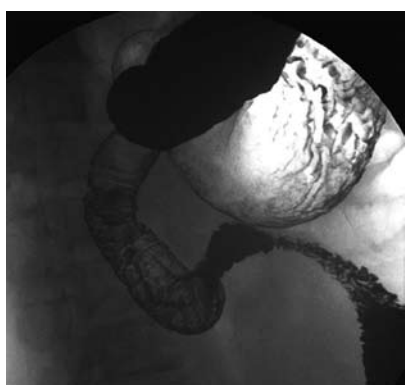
Double contrast radiograph of the duodenum showing an approximately 3-cm peduncular polyp.
